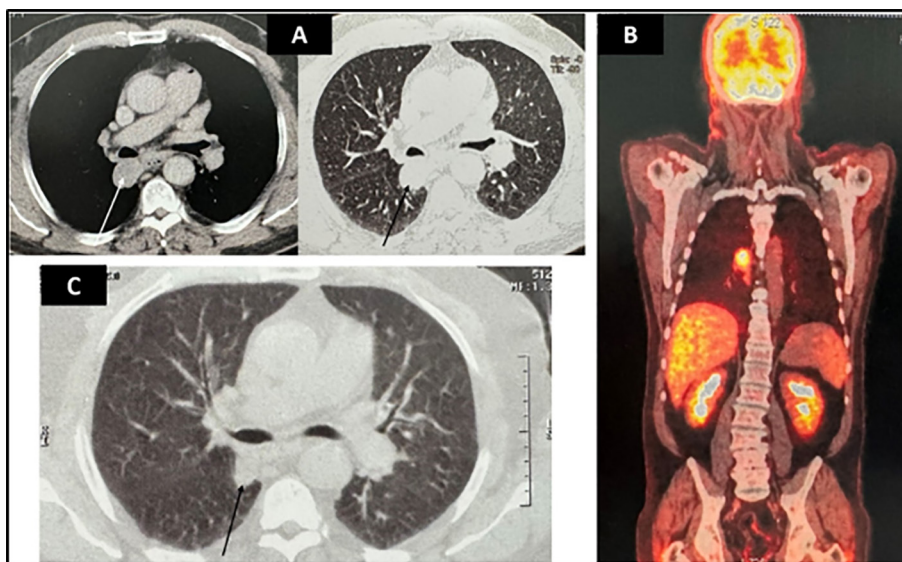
A) The computed tomography (CT) of the chest in mediastinal and parenchymal sections revealed the presence of a pulmonary lesion in the right lower lobe (arrows). B) The positron emission tomography (PET) revealed a hypermetabolic pulmonary parenchymal mass in the right nelson region, without suspicious pathological hypermetabolism in the remaining structures explored. C) The follow-up computed tomography shows a regression of the tumor mass (arrow).
